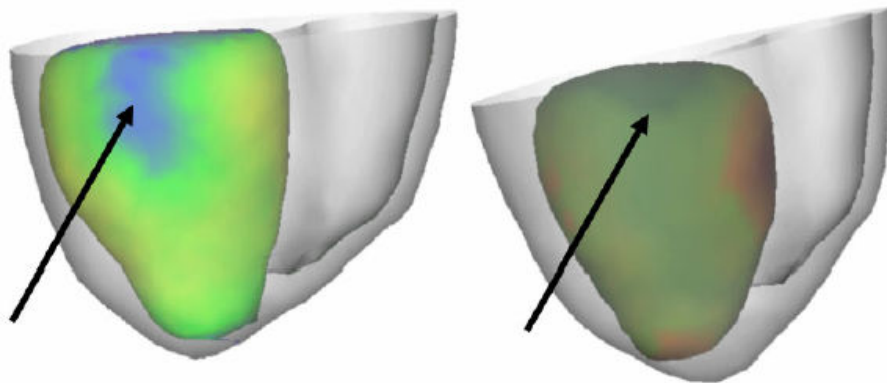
Représentations en 3-D de la captation du FDG (gauche) et de la densité de courant (droite) pour le patient E1 selon un autre point de vue pour une meilleure visualisation de la zone lésionnelle.
